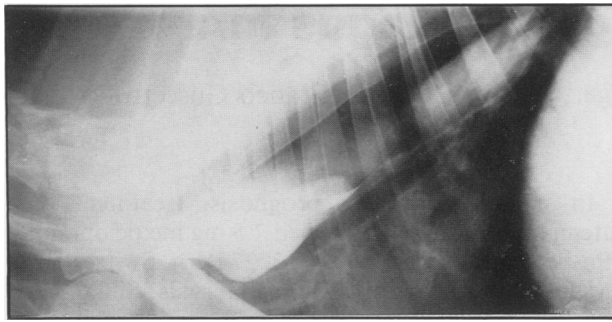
Radiograph: The esophagus is dilated in the thoracic area, and contains barium and gas.
